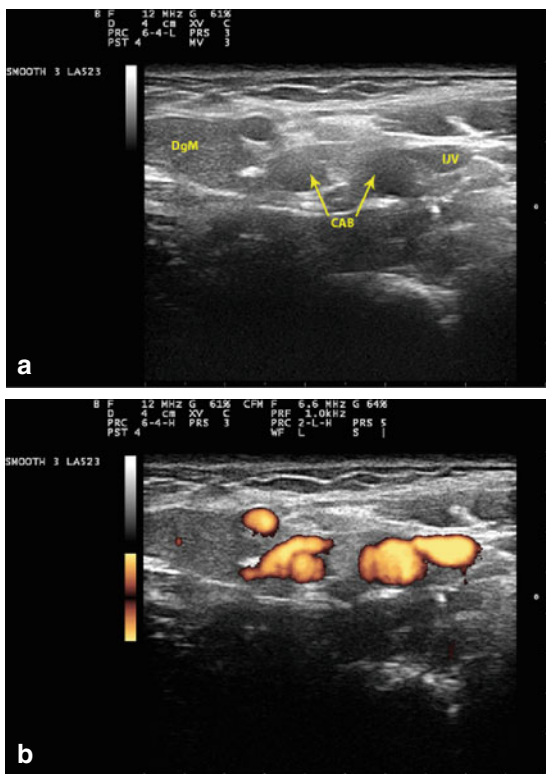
Left neck level II. The transducer is placed slightly superior to the carotid bulb and both carotid branches are visualized in (a). The corresponding findings by Doppler examination are seen in (b). Abbreviations: *DgM* digastric muscle, posterior belly, *CAB* carotid artery bifurcation, *IJV* internal jugular vein
